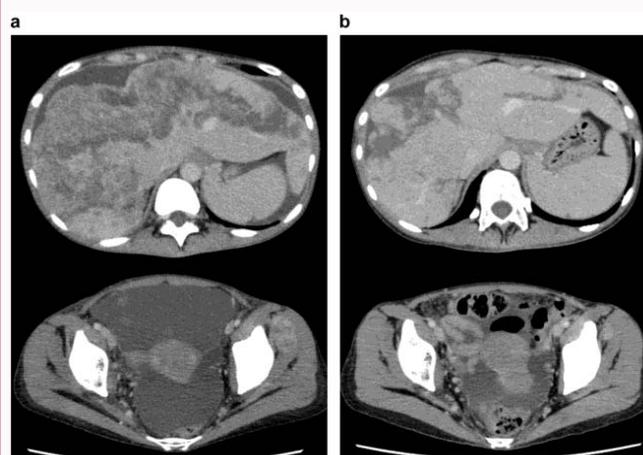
(a) Computed Tomography (CT) before carboplatin/gemcitabine treatment. Approximately 60% of the liver was occupied by cancer, and ascites appeared around the liver and pelvis. (b) CT after four cycles of carboplatin/gemcitabine. The tumor had shrunk and ascites had significantly decreased.
